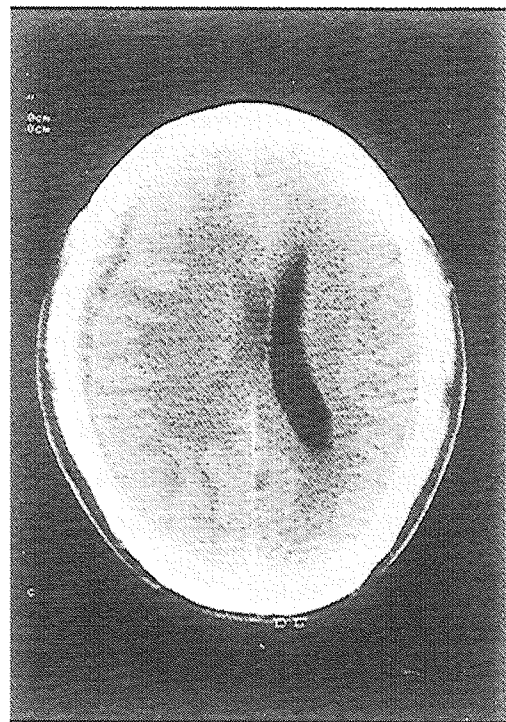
Brain CT scan in patient 1 reveals another hemorrhage in the right side of subdural space in episode 2.
